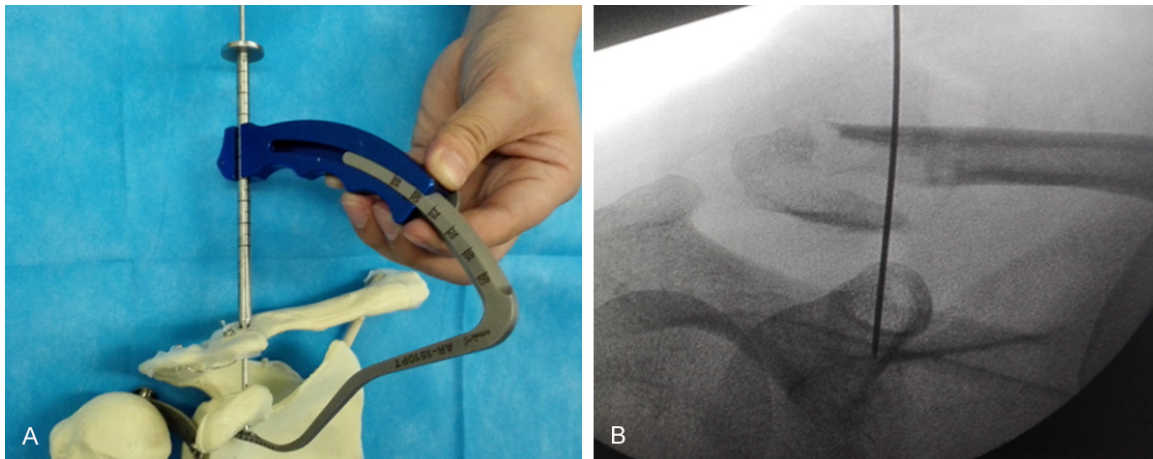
Insertion of the Constant Guide for the AC TightRope with the Coracoid Drill Stop and Graduated Guide Pin Sleeve through the two incisions. Position of the Drill Stop tip under the base of the coracoid as close as possible to the scapula. A. Position of the top of the Guide Pin Sleeve over the superior clavicle at its midline approximately 25 mm from the distal clavicle through a 1.5 cm incision generated in Langers lines by splitting the deltotrapezial fascia. Insertion of a 2.4 mm Drill Tip Guide Pin into the guide pin sleeve and advanced through the clavicle and coracoid using a power drill. The tip of the guide pin is captured by the drill stop at the base of the coracoids under direct visualization. B. The position of the pin in relation to the coracoids should be checked radiographically to ensure that the tip of the guide the pin is centered between the medial and lateral edges of the coracoid.
